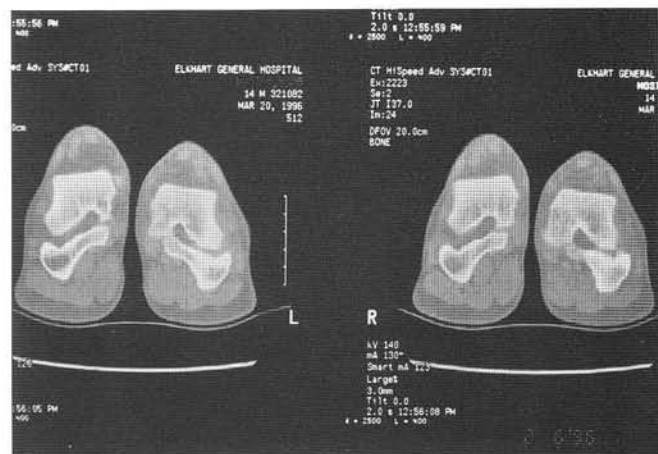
CT scan of patient shown in Figure 1. Notice the malalignment of the subtalar joint on the affected side. There is a loss of joint congruity which correlated with the clinical observations and other radiographic findings. This patient was subsequently diagnosed with Ehlers-Danlos Syndrome which may have contributed to his problem.
